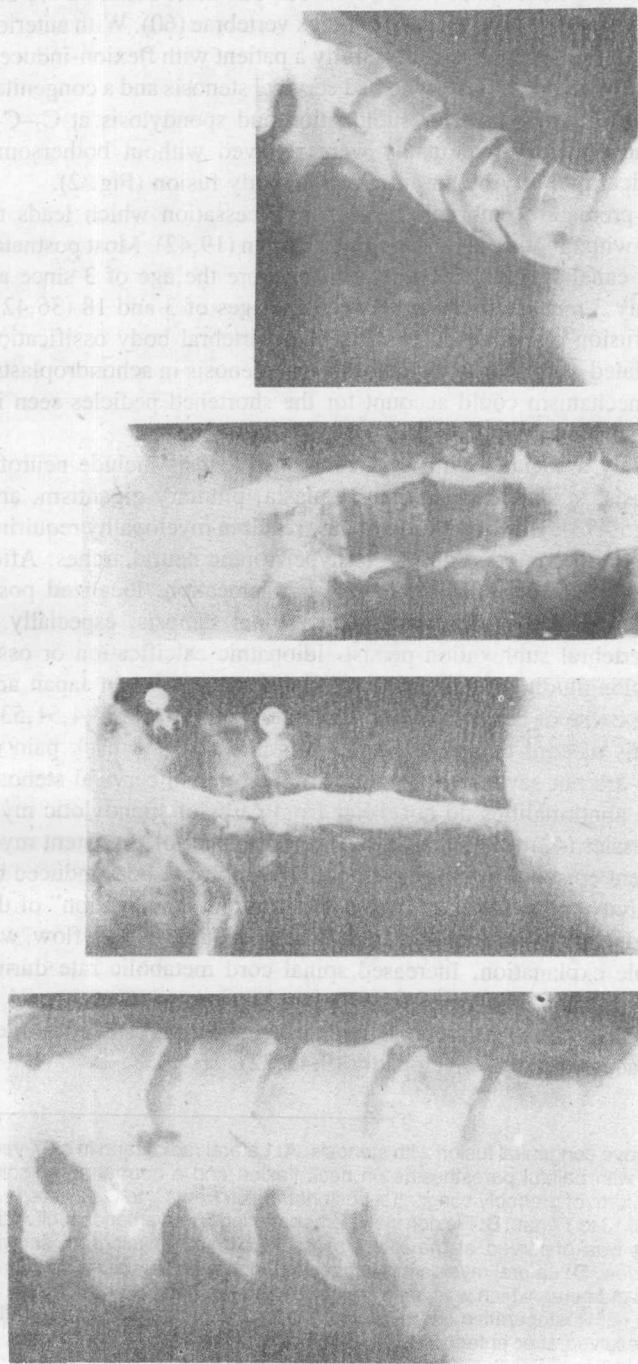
Cervical stenosis. A: Lateral radiograph in a 34-year-old female who presented with progressive weakness and activity-induced incoordination of the right hand, as well as early signs of myelopathy. She had bilateral extensor plantar responses with moderate gait spasticity and a sensory hypalgesia below T₃. Sagittal canal diameter measures 12 mm at C₄-C₅ and C₅-C₆. B: Lateral myelogram demonstrating smooth dorsal and ventral canal surfaces due to diffuse stenosis without spondylosis. C: Anteroposterior (AP) myelogram documenting cord compression with widening of the cord shadow at C₅ and C₆. D: Postoperative lateral radiograph in flexion showing maintenance of spinal stability after wide decompressive laminectomy at C₄-C₆. The patient recovered slowly over 4 months and returned to work as a supermarket cashier.
